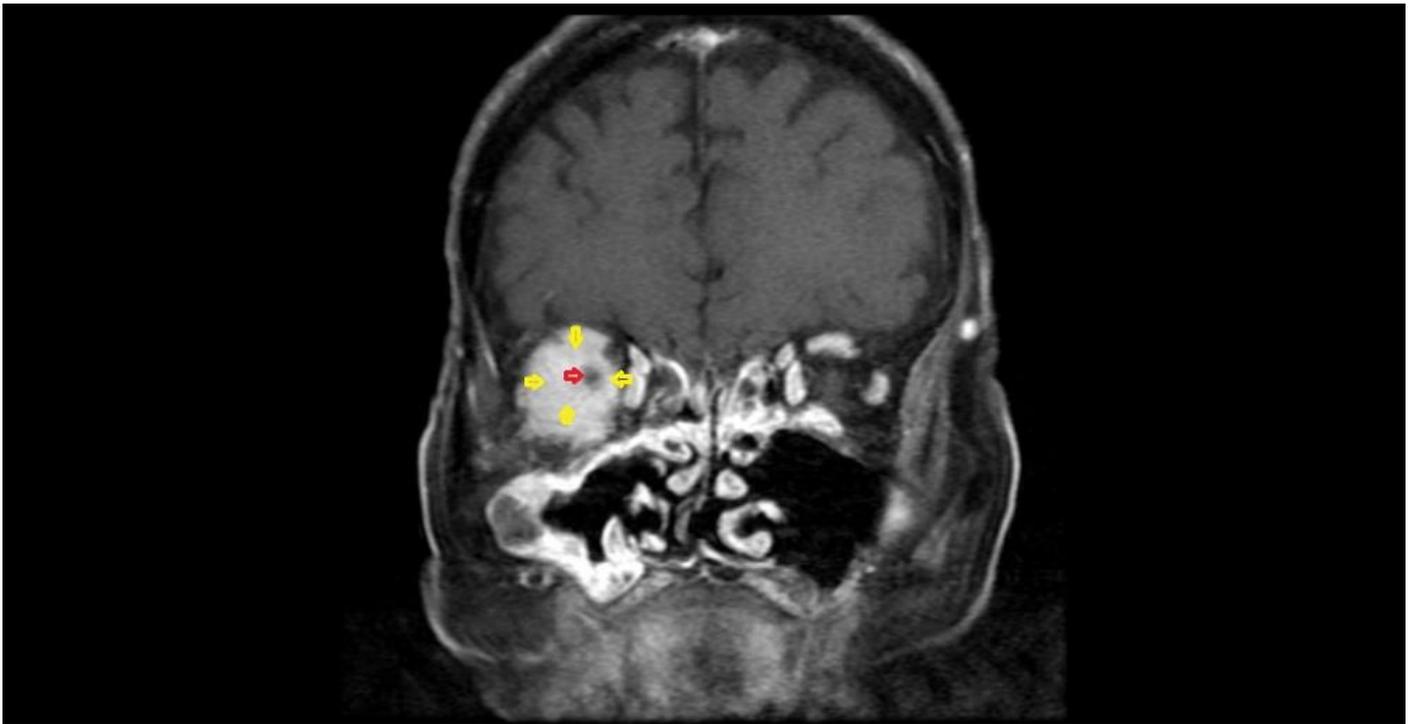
The coronal T1 weighted fat suppressed with gadolinium contrast MRI scan of optic nerve sheath meningioma (yellow arrow) and optic nerve (red arrow)
